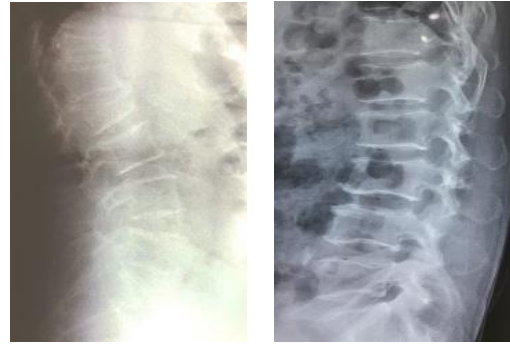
X-ray thoracolumbar lateral views of multilevel thoracolumbar OVF
